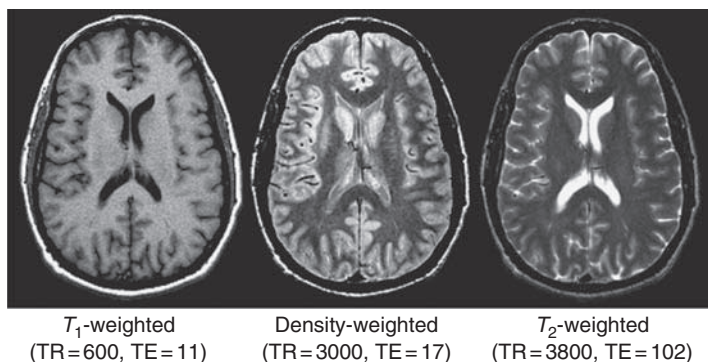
Magnetic resonance images of the same anatomical section showing a range of tissue contrasts. In the first image, cerebrospinal fluid is black, whereas in the last image it is bright. Contrast is manipulated during image acquisition by adjusting several parameters, such as the repetition time TR and the echo time TE (times given in milliseconds), which control the sensitivity of the signal to the local tissue relaxation times T_1 and T_2 and the local proton density.
